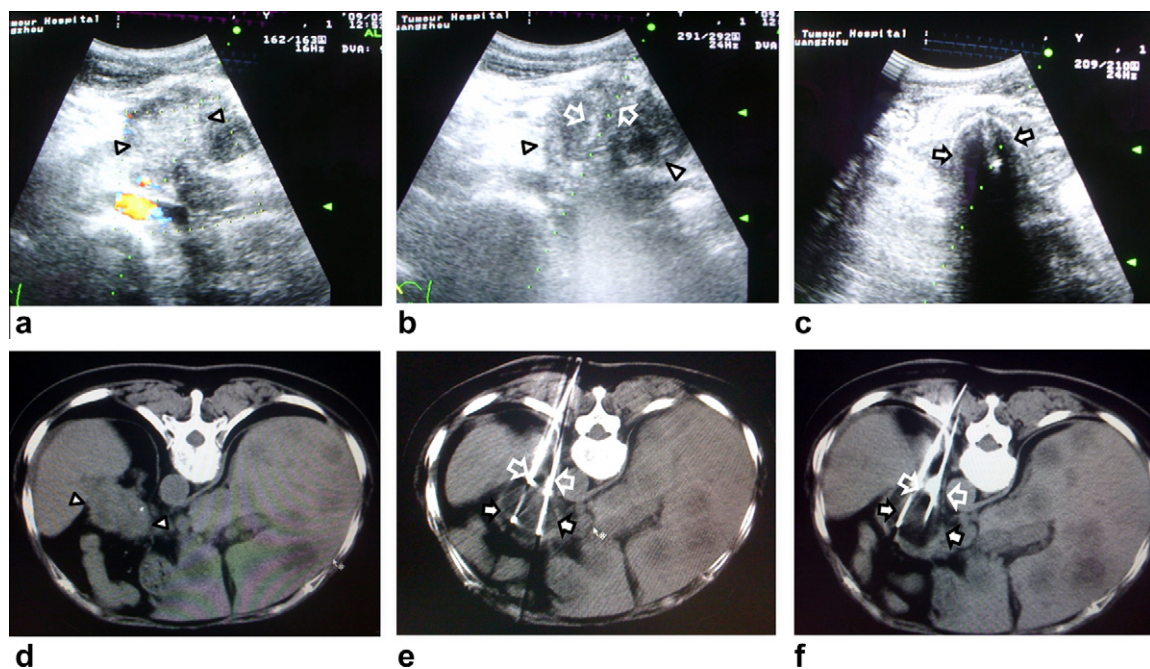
Transabdominal percutaneous cryoablation guided and monitored by US and CT in a 59-year-old patient with tumor in the head of the pancreas (adenocarcinoma,  $3.5 \times 4.0$  cm, stage IV). Under the guidance of US (a) the position of tumor (arrow head) and its adjacent vessels are depicted; (b) three cryoprobes (hollow arrow) were advanced through the stomach to the distal edge of the tumor and initiated freeze–thaw cycles; (c) ice ball (arrow) formation in the tumor. Under the guidance of CT, after the probe had been stuck into the tumor (d), ice ball area turned from small (e) to big (f).
